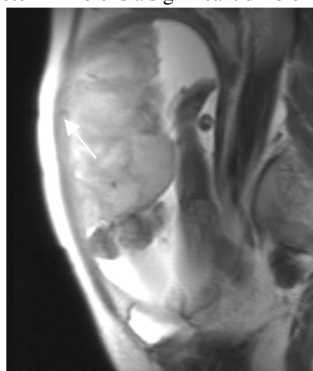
FGR with globular appearance and in decreased FVs a 29-year-old pregnant woman at 33 weeks gestation. T2-weighted RARE image shows the thickened placenta with no tapering edges and decreased size and number of flow voids between the uterus and the placenta (arrow)
